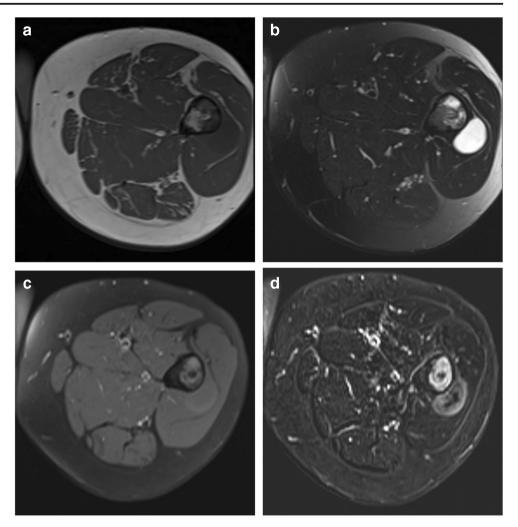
MR images of the left femur. a axial T1, b axial proton density with fat suppression, c axial T1 with fat suppression, d axial T1 with fat suppression post contrast
